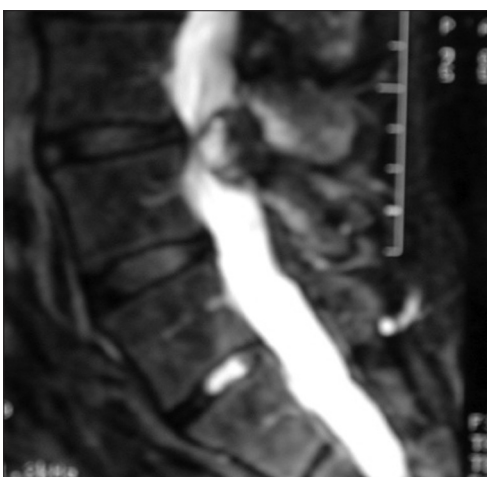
The parasagittal T2-weighted MR demonstrates a heterogeneous dorsolateral cyst resulting in thecal sac compression at the L3–L4 level. Notably, it contains hyperintense, isointense, and hypointense elements
